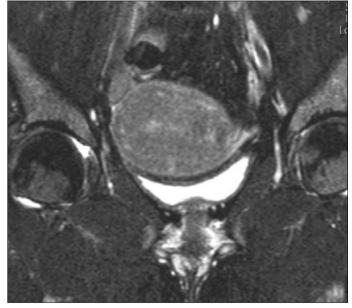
Fat-suppressed T2-weighted coronal pelvic magnetic resonance image shows normal uterus and adnexal structures
